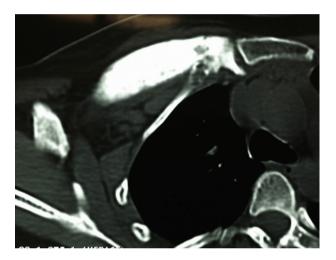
CT scan - sclerotic margins and lytic appearance.
